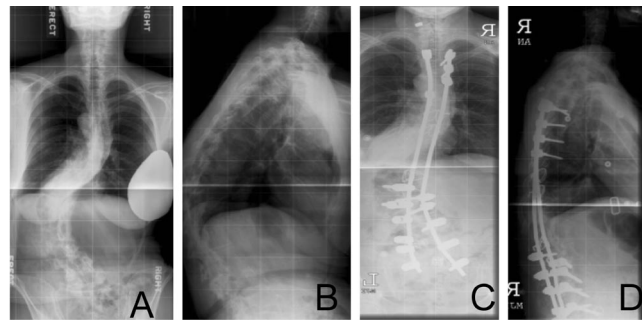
Frontal and lateral radiographs of a patient with severe kyphoscoliosis. A and B, preoperative; C and D, postoperative. Note the substantial correction of both kyphosis and scoliosis with placement of rods. Radiographs courtesy of Serena Hu, MD.
